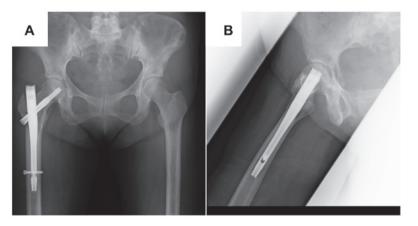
At the final follow-up, X-ray shows sclerotic change of bilateral proximal femurs. (A) Anteroposterior view; (B) Lateral view.
